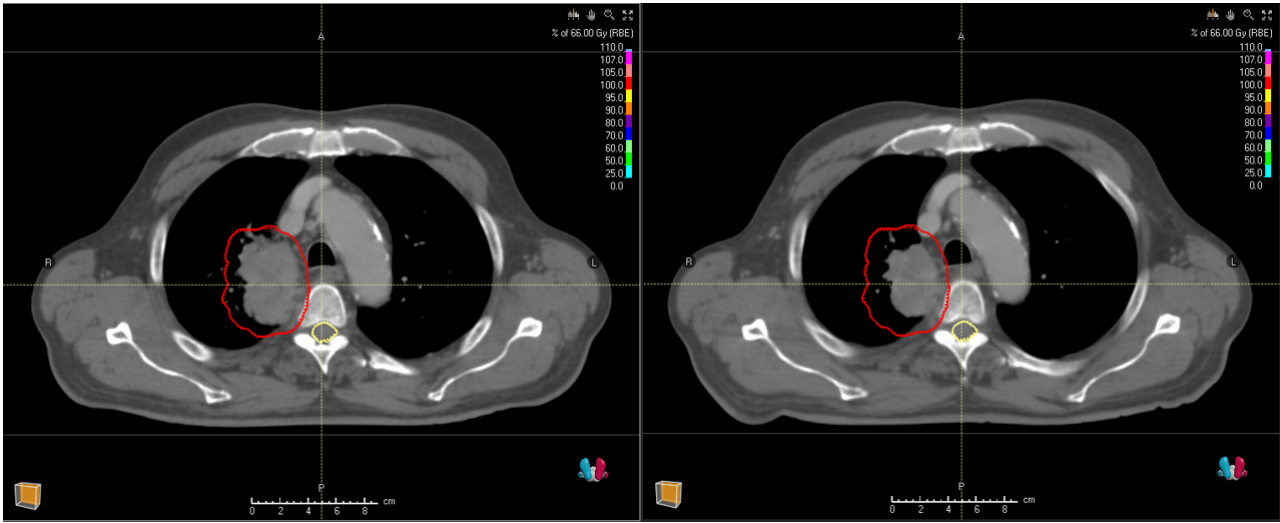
A single CT slice for patient 17 showing tumor shrinkage happening between CT 1 and CT 2 (CT 1 on the left and CT 2 on the right side).
